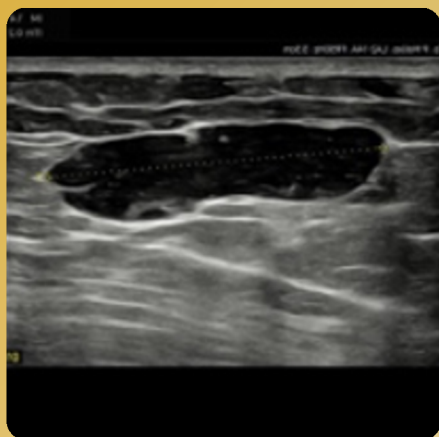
Subcutaneous collection on ultrasound
